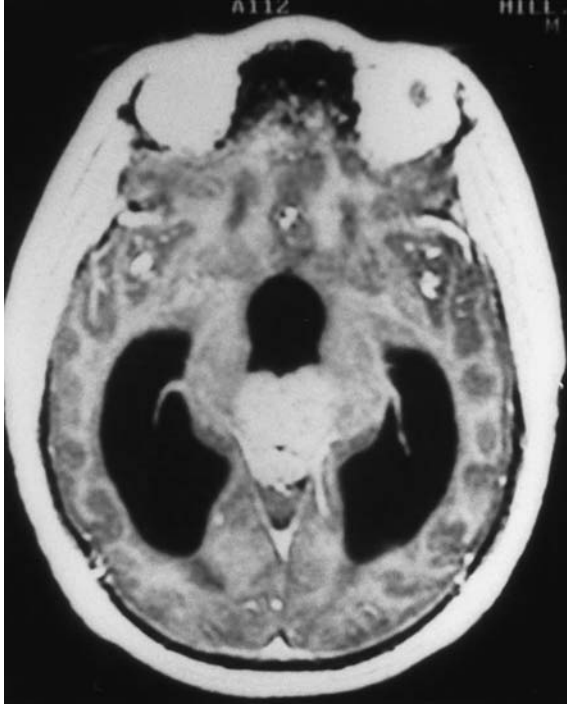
Axial MRI after contrast infusion showing a large germinoma.
